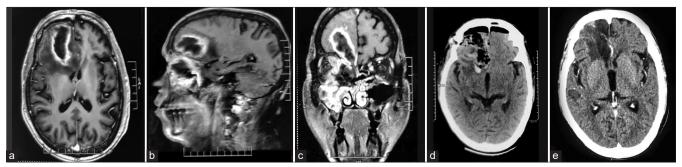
(a-c) A case of rhino-cerebral mucormycosis (RCM) with the right frontal lobe abscess who underwent right frontal craniotomy and excision of abscess, along with combined (open plus endoscopic) debridement of sinuses. (d) Immediate postoperative computed tomography (CT) scan images showing complete excision of the abscess. (e) Postoperative contrast-enhanced CT (CECT) scan images at 3 months follow-up showing no residual lesion.
